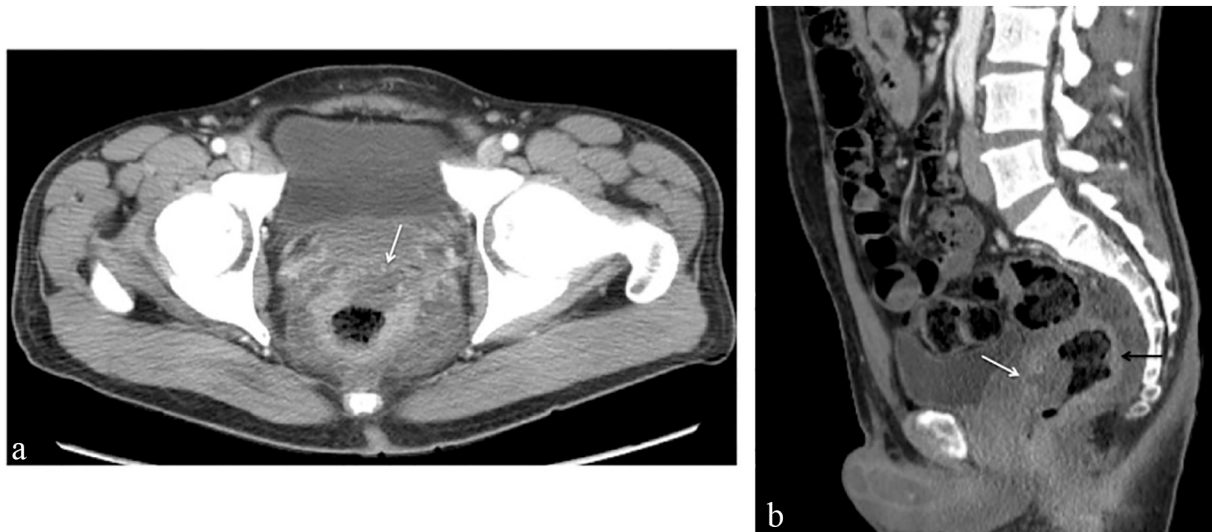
Axial image from contrast-enhanced CT scan 11 days later (a) shows decrease in mural thickening and anterior hypoattenuated ulcer. Sagittal image (b) shows decrease in enhancing posterior rectal wall (black arrow) and large anterior wall hypoattenuated ulcer (white arrow) compared with prior exam. Pelvic ascites resolved (not shown).
